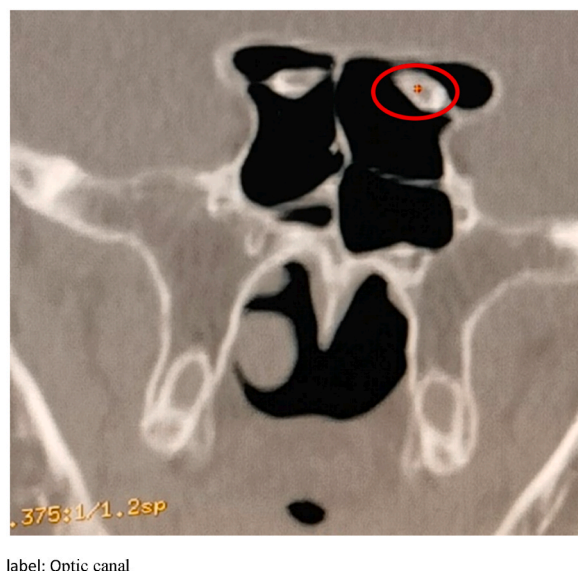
The computed tomography scan of case 2. Circled in red shows that the optic canal was suspended in the sphenoid sinus.
